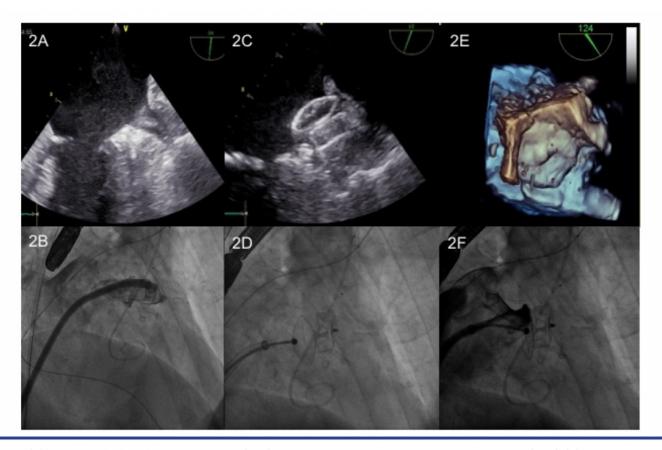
(A) Transesophageal echocardiography (TEE) showing thrombus in the left atrial appendage (LAA). (B) Angiography of the LAA. Amplatzer Amulet device was deployed and its stability was confirmed by Minnesota maneuver at (C) TEE and (D) fluoroscopy. (E) Three-dimensional TEE showing the Amplatzer Amulet device in place. (F) No leaks were documented at final angiography.
